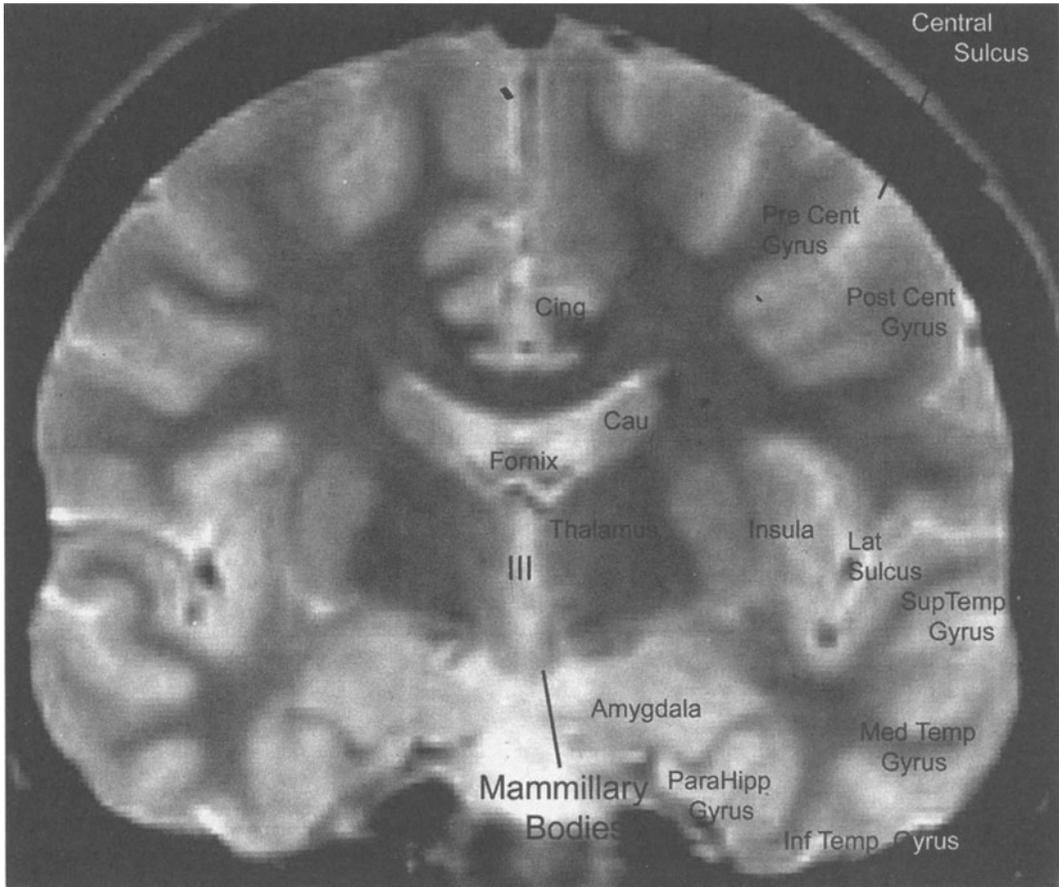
Coronal Section through mammillary bodies and amygdala. MRI-T2.
